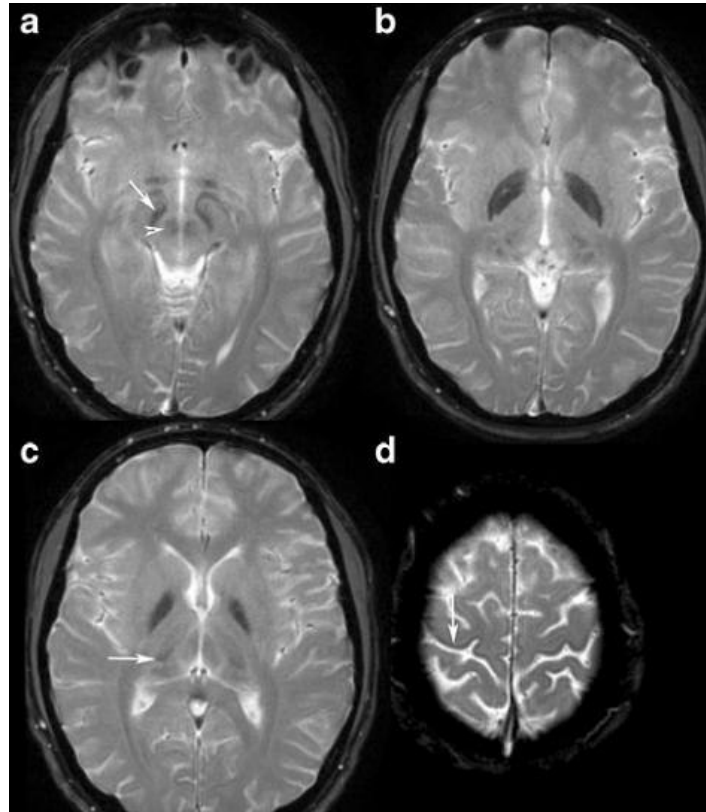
Axial T2*-weighted MRI of an individual with neuroferritinopathy
